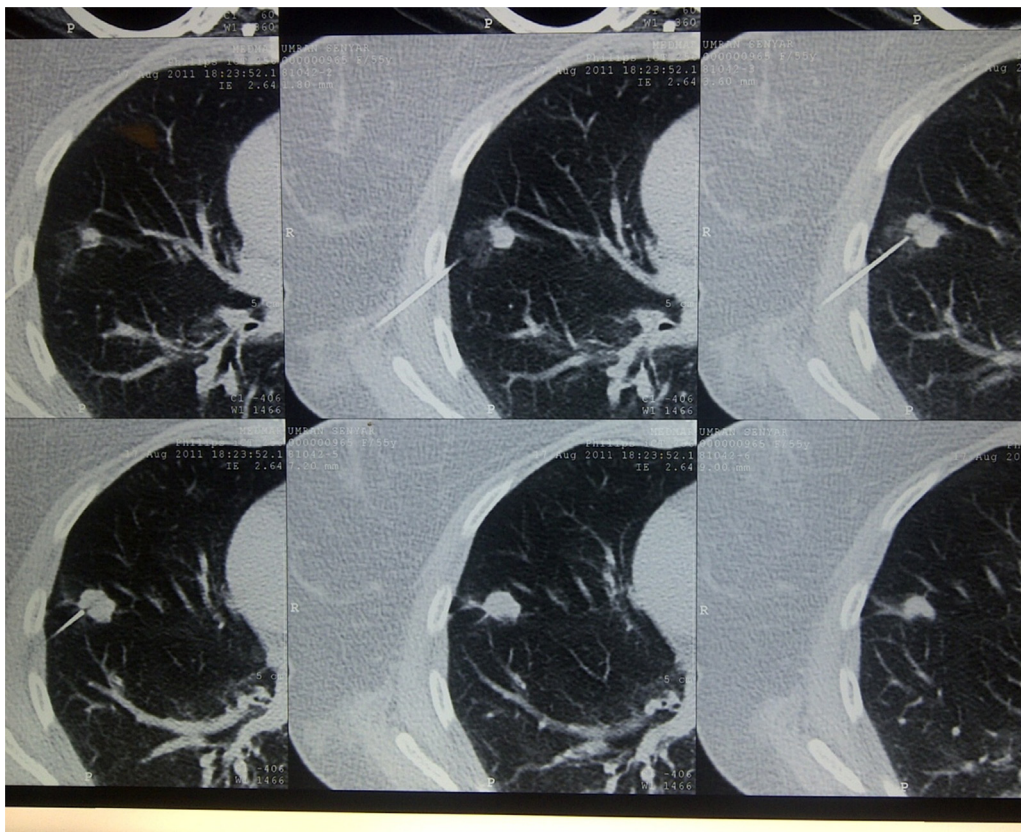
Transthoracic fine needle aspiration biopsy.
